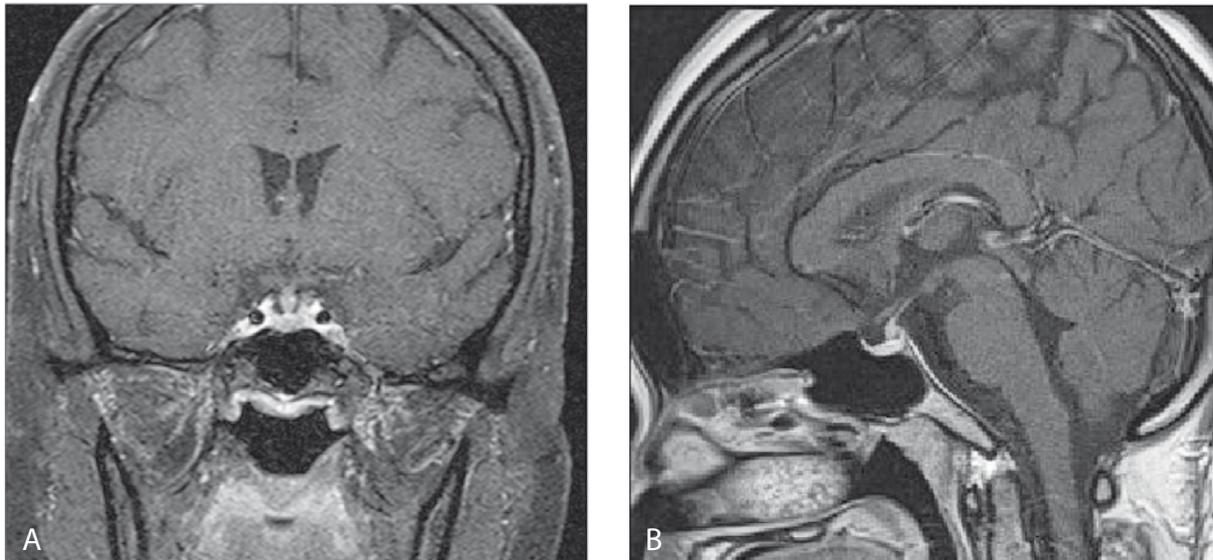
Coronal (A) and Sagittal (B) MRI images of the brain of the patient, showing thickening of the pituitary stalk and loss of the posterior pituitary hyperintense signal
